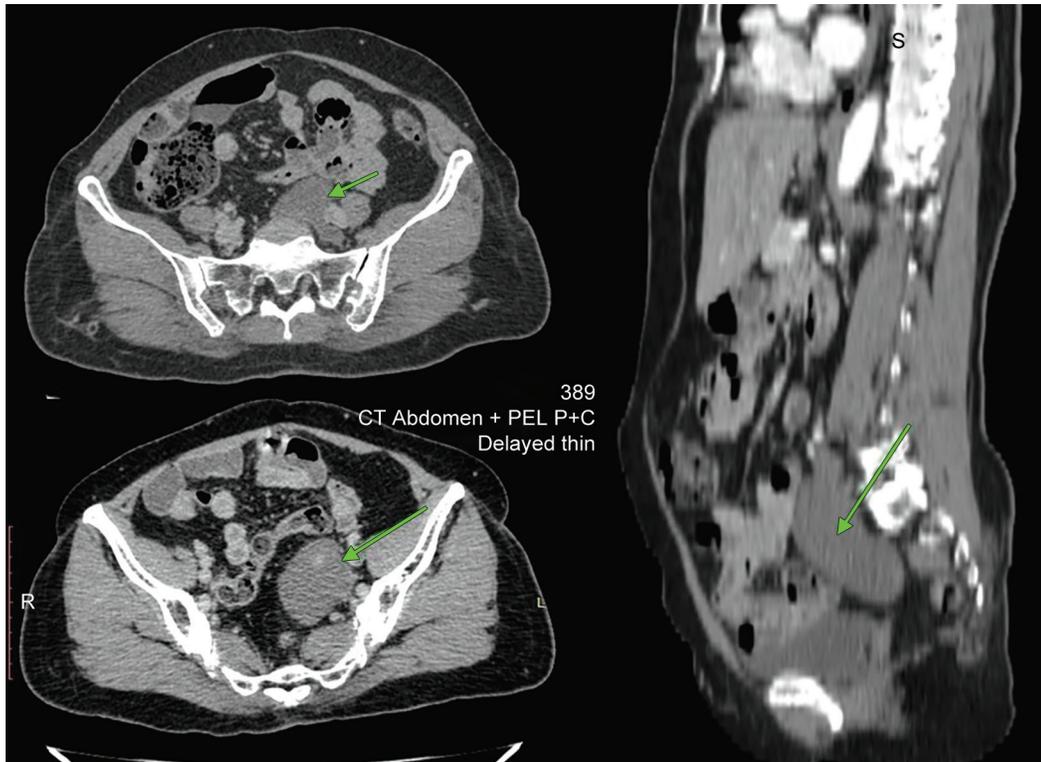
Axial and sagittal sections of the contrast-enhanced computed tomography showing the mass in the left side of pelvis
